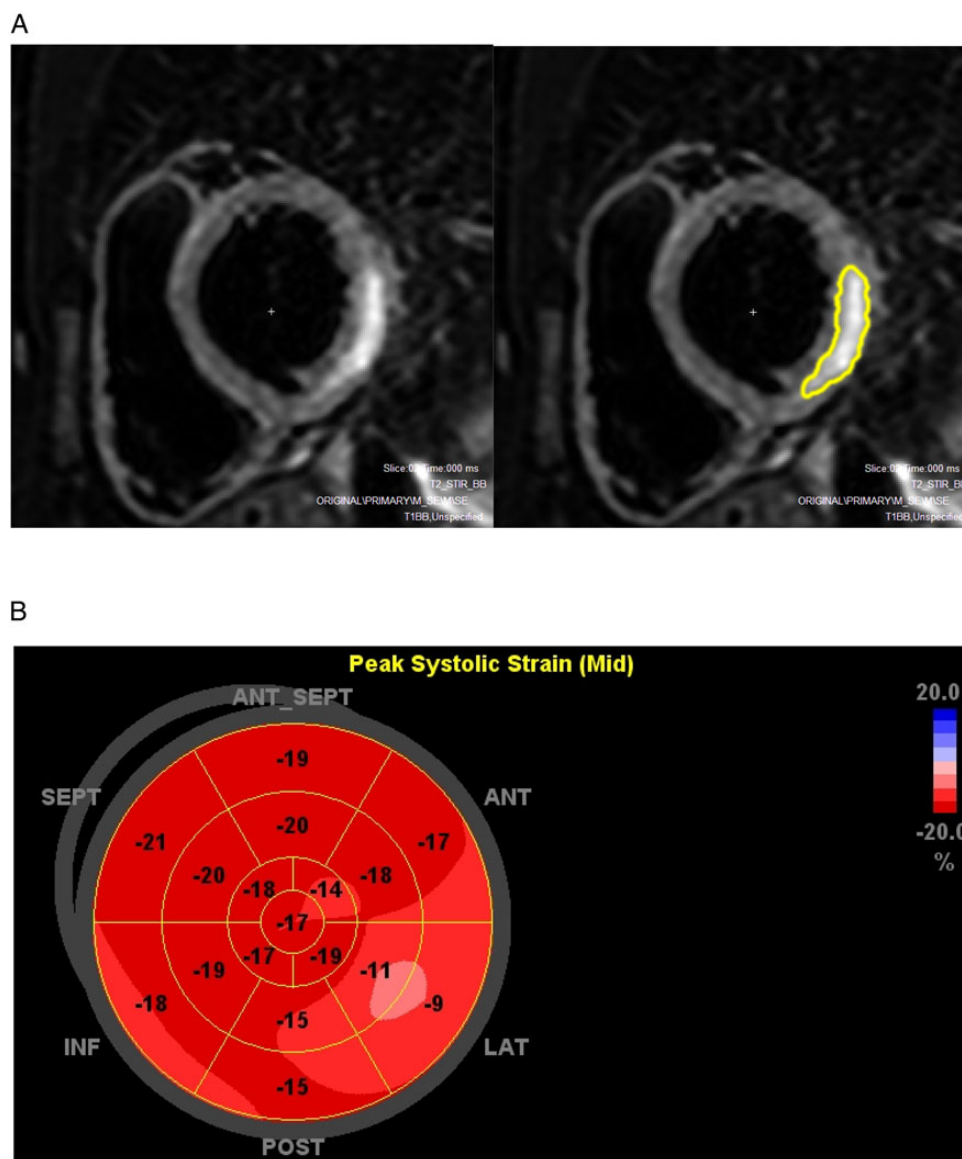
CMR image showing oedema in the LV and the oedema tracing (A). The corresponding deformation analysis according to myocardial layer by echocardiography is shown in B, C, and D. (B) Global systolic strain values showing the exact localization as visualized by CMR. (C) Epicardial strain values showing more decreased values compared with endocardial strain (see D). (D) Endocardial strain values.
